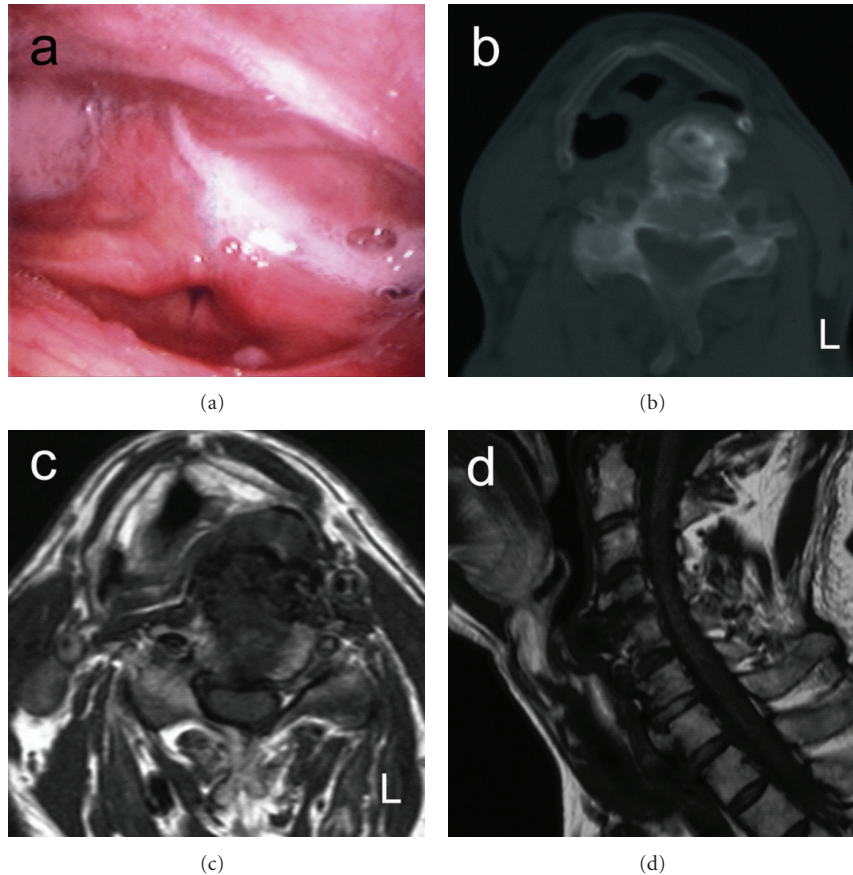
(a) a hard mass protruding in the posterior hypopharyngeal wall. (b) CT scan shows a bony mass pushing the posterior piriform sinus wall anteriorly. (c) Axial T1 weighted-MRI shows a mass pushing the posterior piriform sinus wall anteriorly. (d) sagittal T1 weighted-MRI shows an anterior mass of the cervical spine from C4 to T1.
